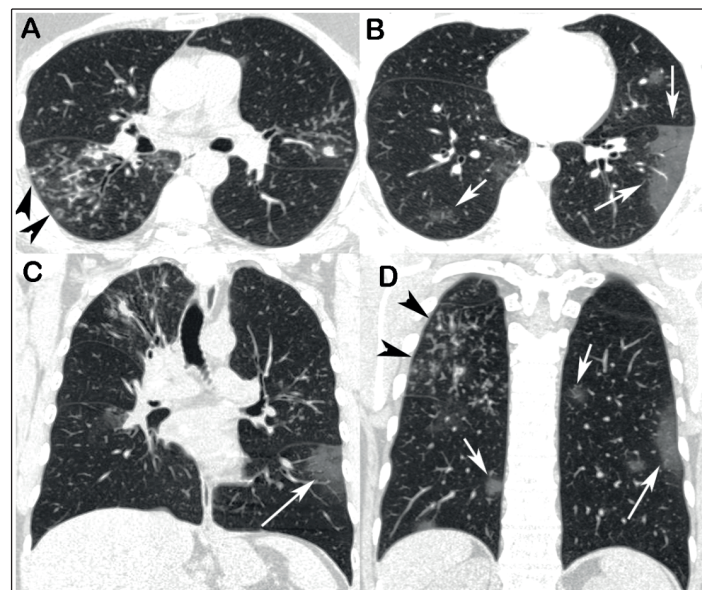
Unenhanced chest CT images with axial (A and B) and coronal (C and D) reconstructions showing “tree-in-bud” opacities predominating in the right lung (black arrowheads), with bronchial wall thickening and small nodules. Note also the multifocal ground-glass opacities in both lungs (white arrows). No pleural effusion or lymph node enlargement was present.
